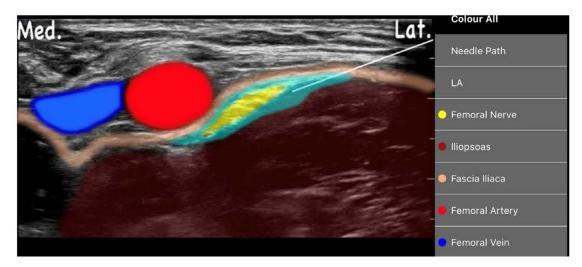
Femoral nerve under ultrasound (with colored anatomy).
